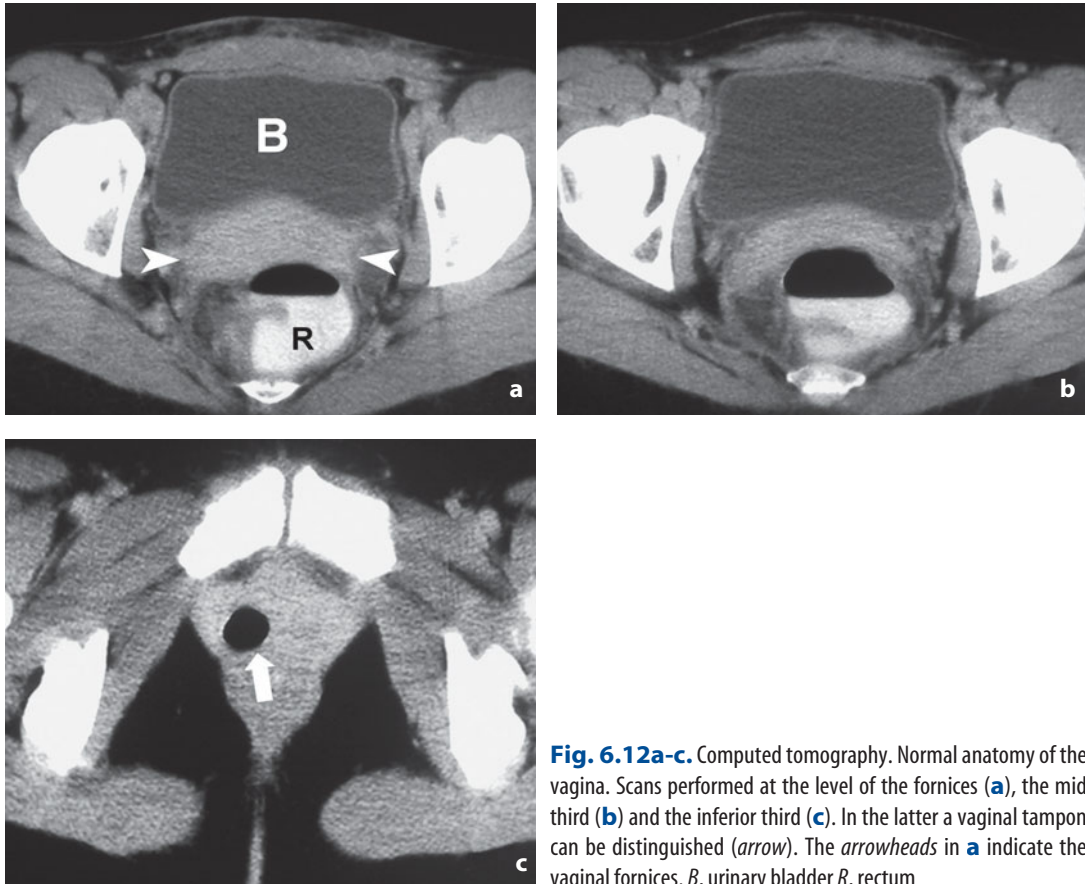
Computed tomography. Normal anatomy of the vagina. Scans performed at the level of the fornices (a), the mid third (b) and the inferior third (c). In the latter a vaginal tampon can be distinguished (*arrow*). The *arrowheads* in a indicate the vaginal fornices. *B*, urinary bladder *R*, rectum
